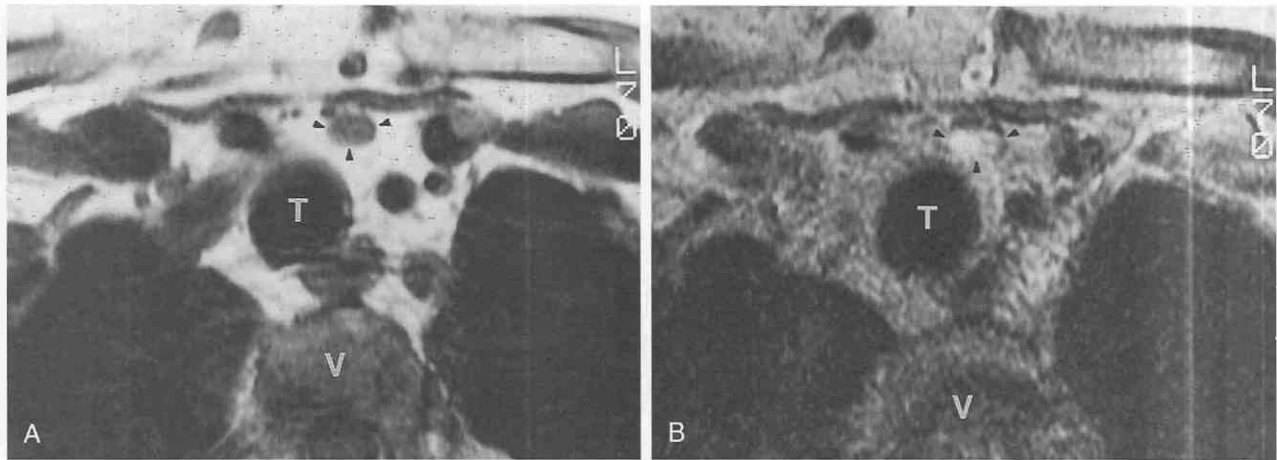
Ectopic parathyroid adenoma in a woman with persistent hyperparathyroidism after surgical neck exploration. MR images show 1-cm mass (arrowheads) in anterior mediastinum with intermediate signal intensity (similar to muscle) on T1-weighted image (A) and high signal intensity on T2-weighted image (B). MR appearance is typical of parathyroid adenoma. T, trachea; V, vertebral body. (Reprinted with permission from Erasmus JJ, McAdams HP, Donnelly LF, Spritzer CE: MR imaging of mediastinal masses. *Magn Reson Imaging Clin North Am* 8:59-89, 2000.)
